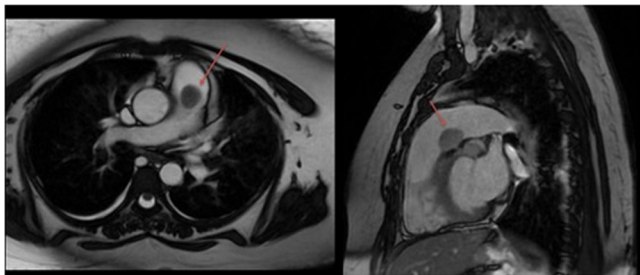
Axial and sagittal T2-weighted sequences of a cardiac MRI demonstrating a hypointense ovoid lesion in the posterior aspect of the pulmonary trunk (red arrows). MRI, magnetic resonance imaging.
